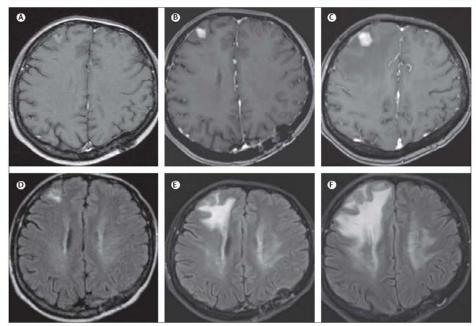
True progression of brain metastasis Axial contrast-enhanced T1-w (A-C) and FLAIR images (D-F) of melanoma metastases before (A, D), during therapy with ipilimumab (B, E), and 3 months later (C, F). Note the constant increase in the extent of the contrast enhancing lesion and perifocal oedema.
